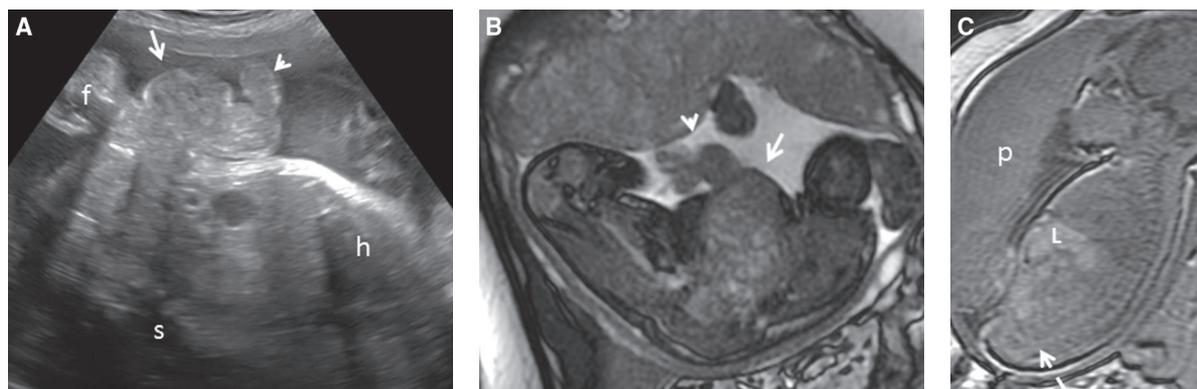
US and fetal MRI at 33 weeks of gestation. A: Sagittal oblique US image shows a protruding “mass” (arrow) in the infraumbilical abdominal wall with a tubular extension (arrowhead) representing the “elephant trunk-like” image. Spine (*s*), femur (*f*), and heart (*h*) are labeled. B: Axial 2D FIESTA. There is absent bladder despite normal amniotic fluid volume and protruding anterior pelvic contour (arrow) with a tubular extension (arrowhead), the prolapsed terminal ileum. C: Sagittal midline T1-weighted MRI shows lack of bright meconium signal in the rectum (dashed arrow). Liver (*L*) and placenta (*p*) are labeled.
